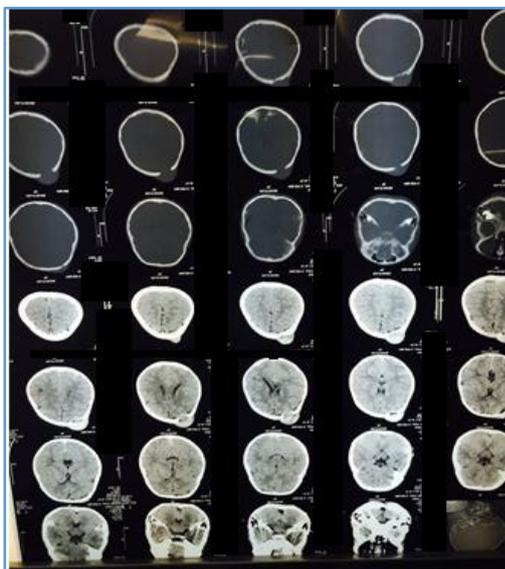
CT brain showing Extracranial Hyperintense soft tissue lesion in the right frontoparietal region in both the inner and outer table with Calvarial defect with compression of the brain Parenchyma
